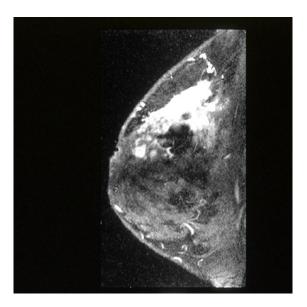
(a) MRI of individual breast, demonstrating marked enhancement (bright area) which was confirmed to be cancer (National Cancer Institute, February 1994)
